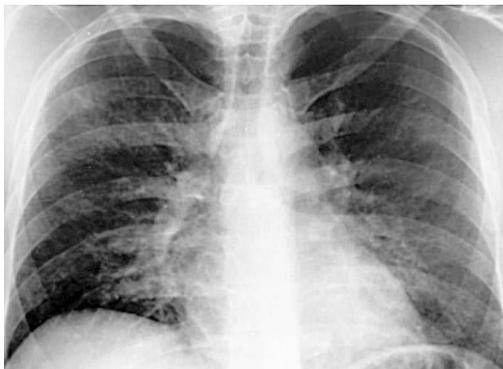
Chest X-ray showing bilateral lung infiltrates (Adapted from reference 6)
